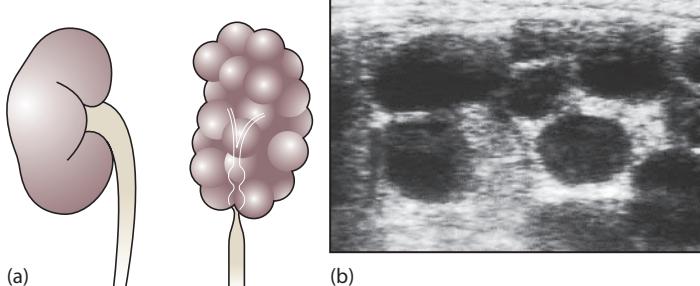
(a) Normal left kidney and multicystic dysplastic kidney (MCDK) on right. The kidney is replaced by cysts of variable size, with atresia of the ureter; and (b) renal ultrasound showing multiple discrete cysts of variable size.
